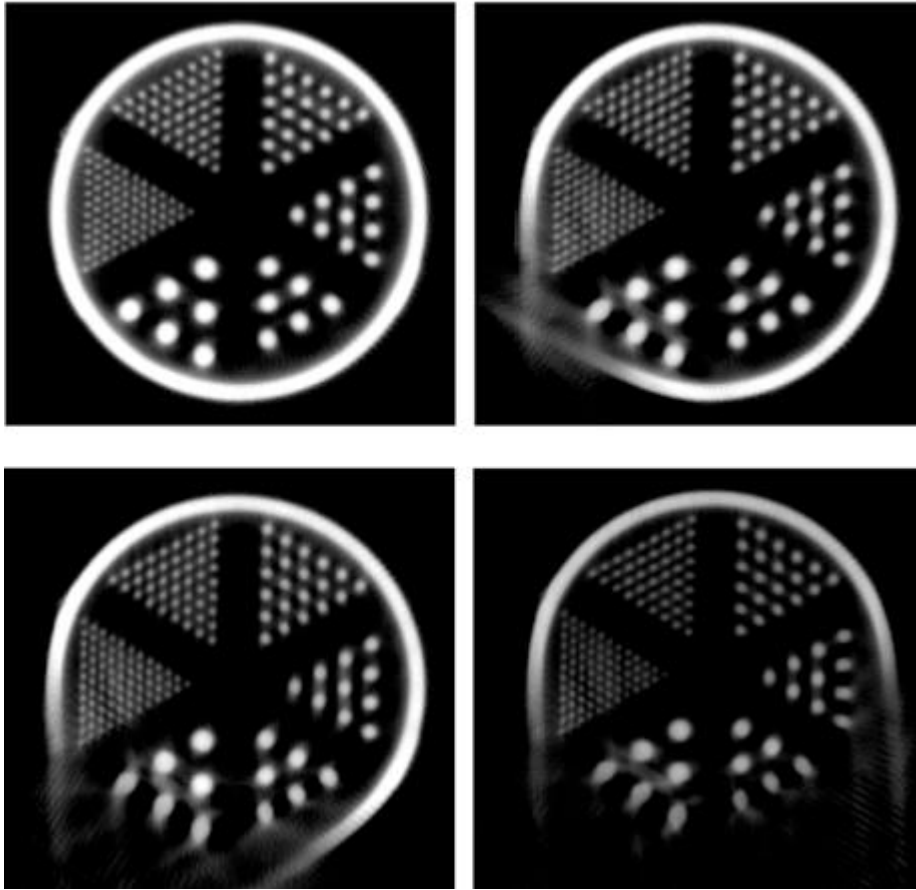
OSTR Reconstructed CT cold rod data acquired with the central cone-beam ray offset 5cm from the COR. Scan angles are (Top Left) 360°, (Top Right) 300°, (Bottom Left) 240°, and (Bottom Right) 180°. Data insufficiency artifacts become more apparent with decreasing angular sampling. (thanks to Spencer Cutler for this figure and caption)
